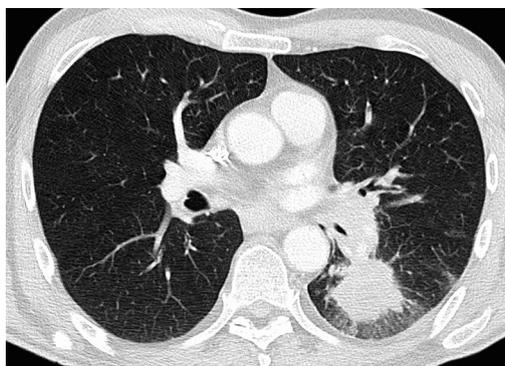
Computed tomography (CT) scan of the chest of a male patient with adenocarcinoma in the lower left lung (at right)
